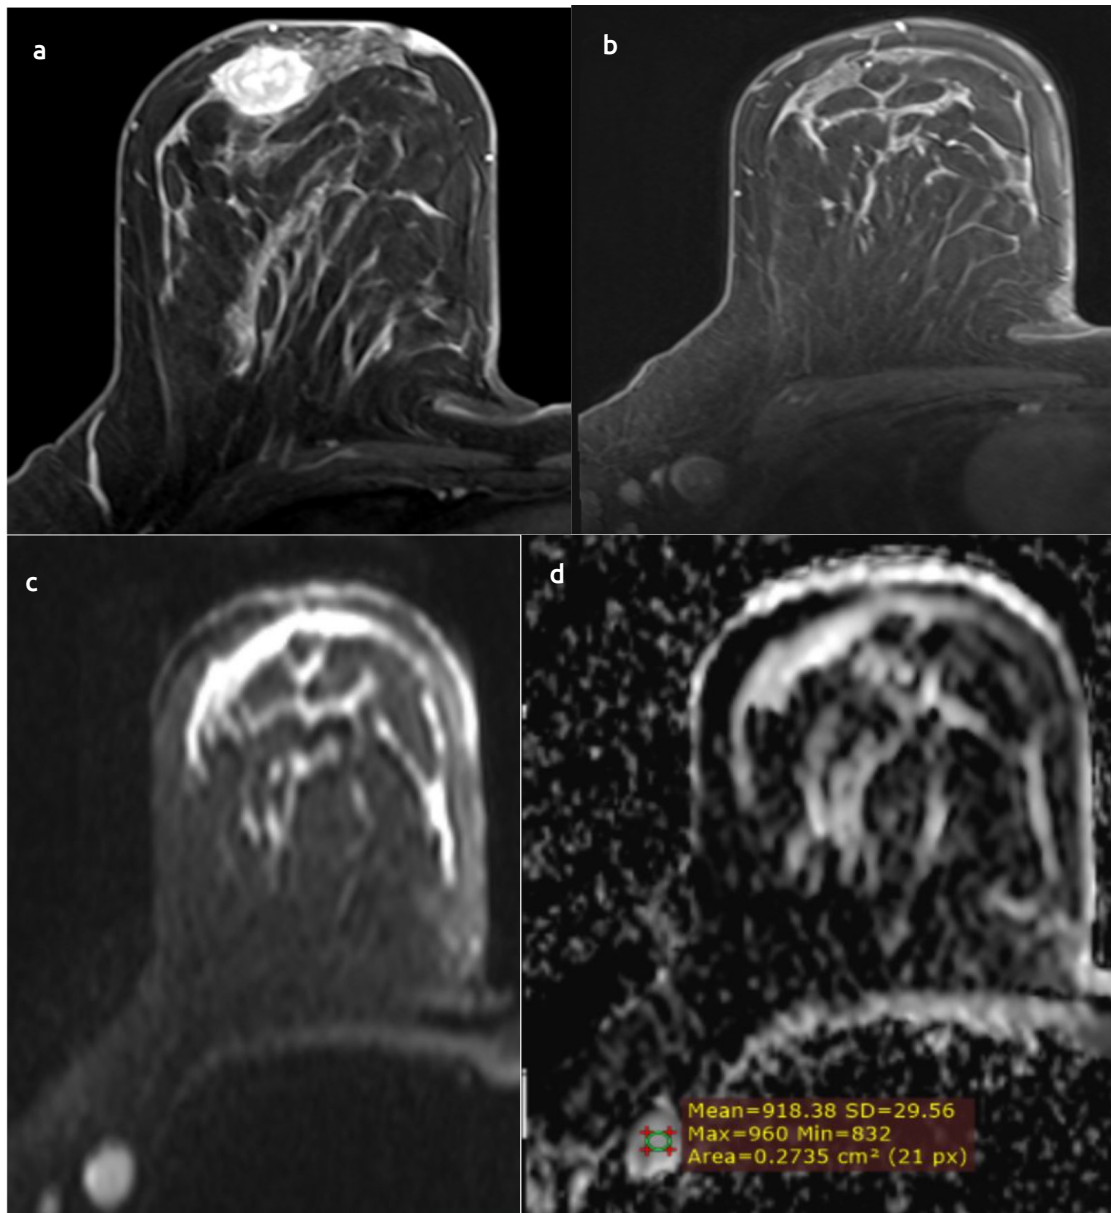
Thirty-two years old female with luminal B right breast cancer. Post-operative pathology revealed: Grade II invasive duct carcinoma associated with high grade ductal carcinoma *in situ* about 5%. No lymphovascular invasion or perineural spread. Ki-67: Positive nuclear reaction in about (20) % of tumor cells. a. Post contrast subtraction MRI image showing malignant looking irregular mass in right breast b. Post contrast MRI subtraction image showing ipsilateral enlarged suspicious axillary LN (white arrow). c. Diffusion image showing high SI of the LN. d. ADC map showing low SI and restricted diffusion of the LN. Mean ADC value of this LN was $0.905 \times 10^{-3} \text{ mm}^2/\text{s}$
